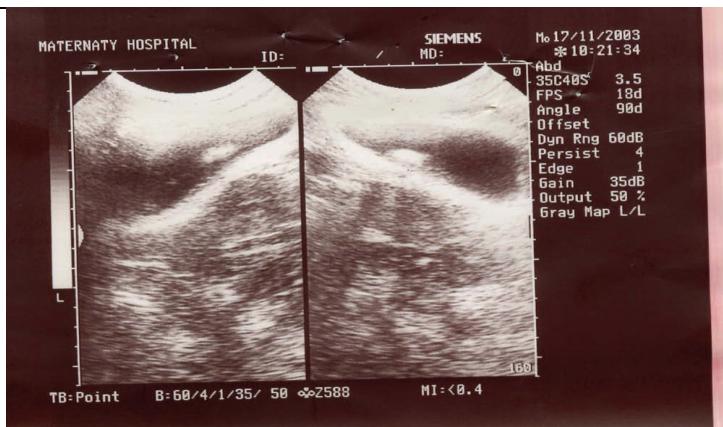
Ultrasound of the urinary bladder , showing the stone with suspicion of foreign body with it.
